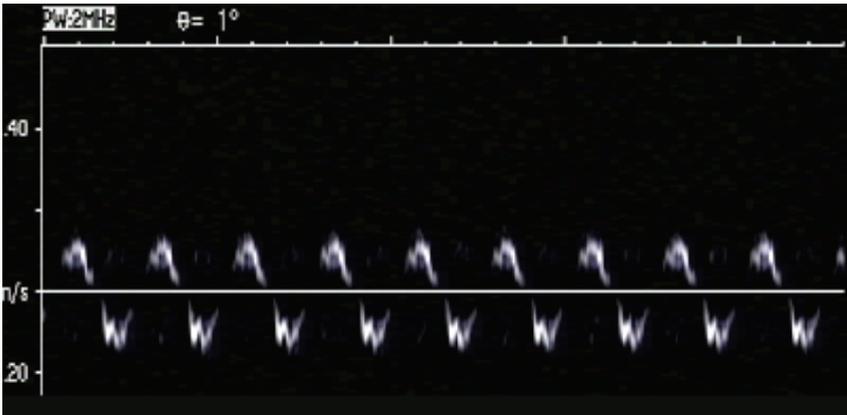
Doppler signal derived from only the motion of the tubing. The fiber-water slurry is within the tubing but is not being pumped. The Doppler signal is generated entirely by the motion of the tubing, reflected by the fiber-water slurry
